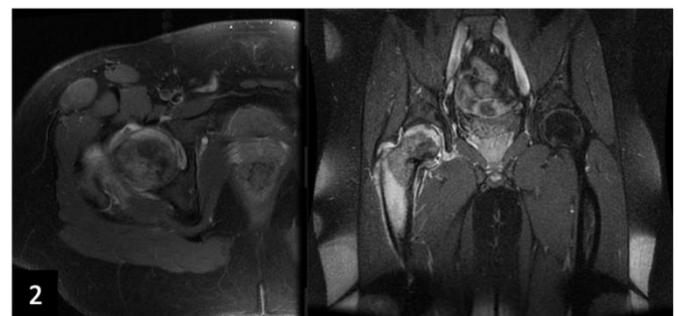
Figure 2: MRI with osteogenic lesion in proximal femur with cortical rupture and soft tissue mass.
